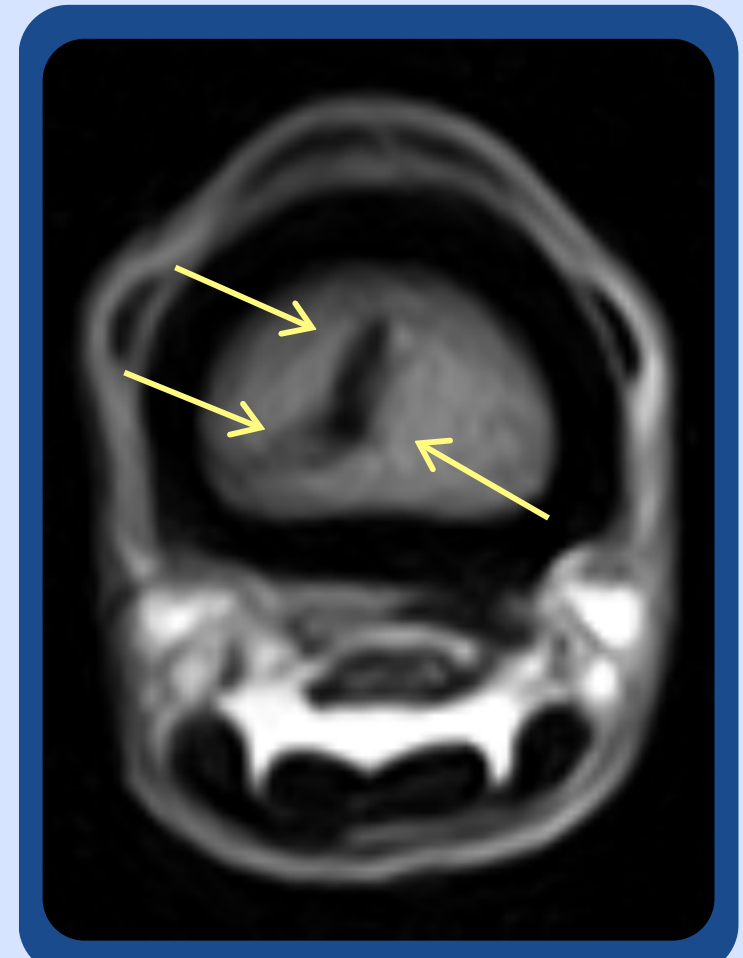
T2*W GRE TRA FAST - L Transverse MRI view of stress fracture in P1, highlighting orientation of P1 fracture line.
